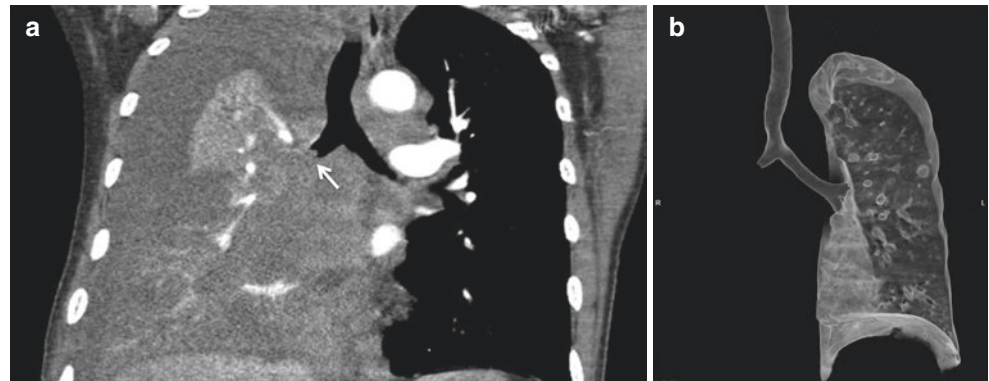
Coronal contrast-enhanced chest CT (a) in a patient with squamous cell carcinoma demonstrates soft tissue occluding the right main bronchus (*arrow*) with total collapse of the right lung, inseparable from malignant tissue. Volume-rendered virtual bronchoscopy was created from the original contrast-enhanced chest CT dataset (b)
